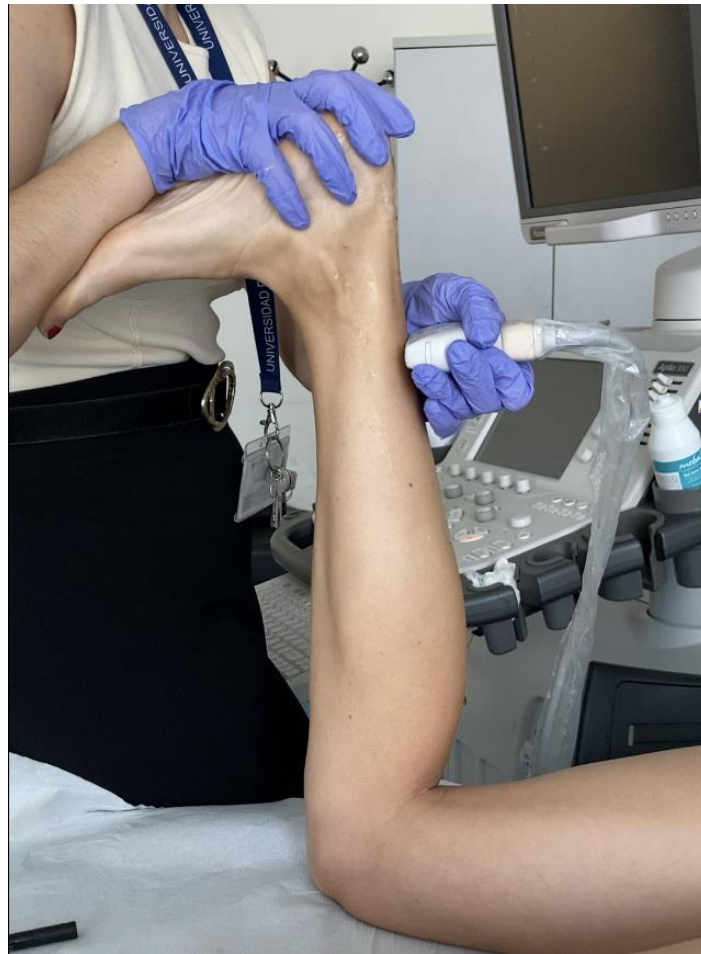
Ultrasound measurements with passive force.
